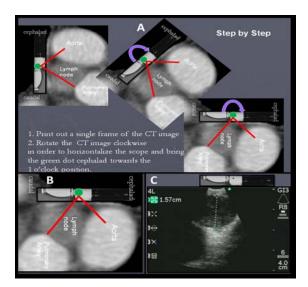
A. Coronal CT image adjustments are made to bring the green dot cephalad as in the EBUS image. B. Coronal CT image is projected as if the EBUS scope is horizontal. The aortic arch is cephalad and the pulmonary artery is caudal. C. EBUS image, being projected by default as if the scope is horizontal, shows the same structures as the adjusted coronal CT image.
